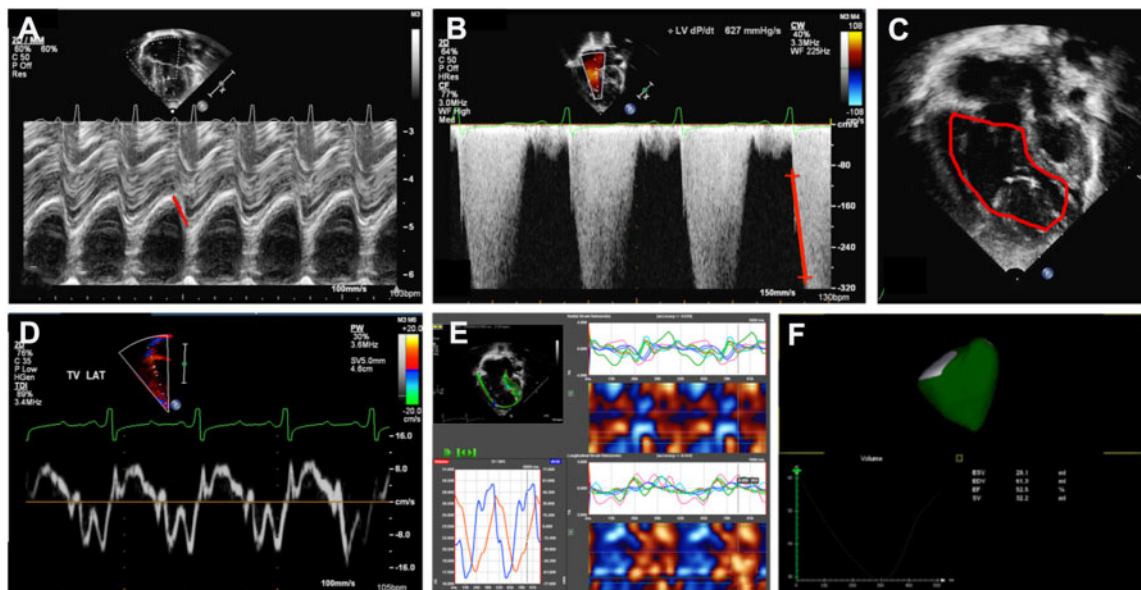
Echocardiographic assessment of right ventricular function. (A) Tricuspid annular plane systolic excursion; (B) right ventricle; (C) dP/dT fractional change area; (D) tissue Doppler imaging; (E) speckle tracking; 3-dimensional right ventricular volume and (F) functional analysis. dP/dT: change in pressure/change in time; LV: left ventricle; TV: tricuspid valve.
